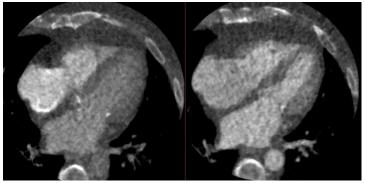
CT perfusion images of the cardiac myocardium. Evaluated in a 70-year-old man with atypical symptoms of angina pectoris. Coronary CT angiography showed no significant coronary artery lesions and no perfusion defects.
